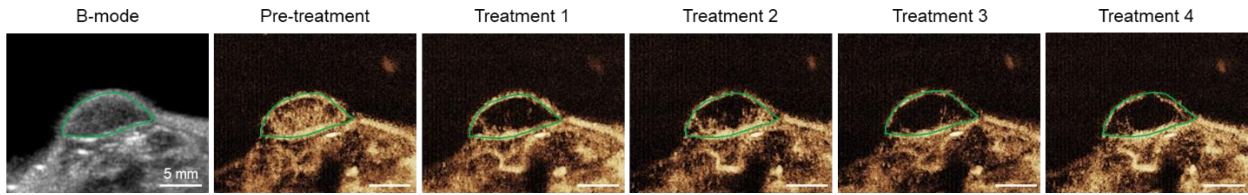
B-mode and maximum intensity projection (MIP) contrast-enhanced ultrasound (CEUS) images during treatment for the moderate cavitation (A) and high cavitation group (B).
